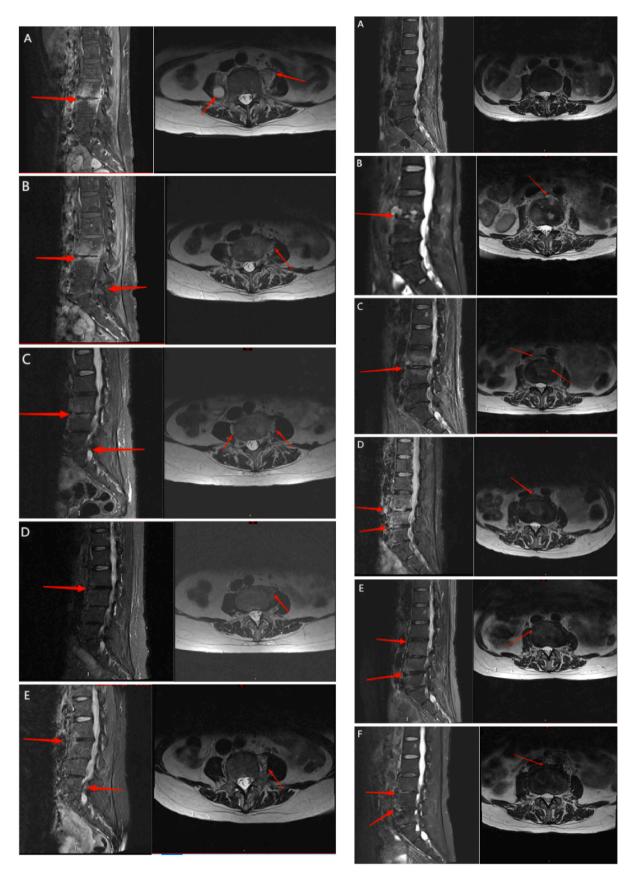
Contrast enhanced midsagittal and axial T1-weighted magnetic resonance images(MRI) show spondylodiscitis. Figure 1.1 MRI image changes of sister. Figure 1.2 MRI image changes of elder sister.
